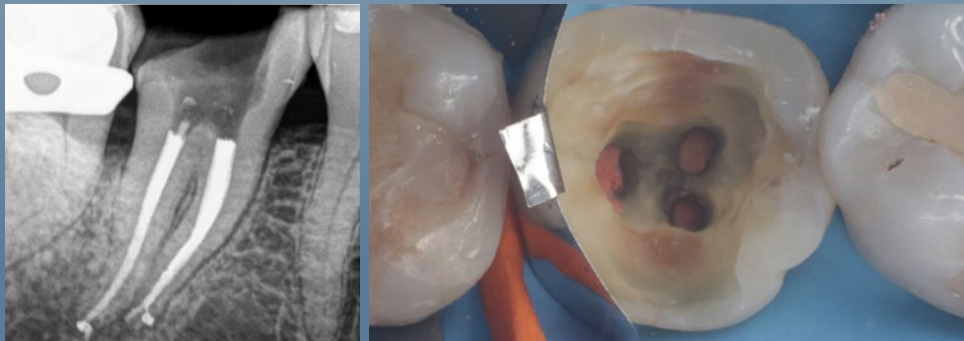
Clinical and radiographic evaluation of the affected molar following completion of endodontic treatment and prior to reconstruction of the lost tooth structure.
